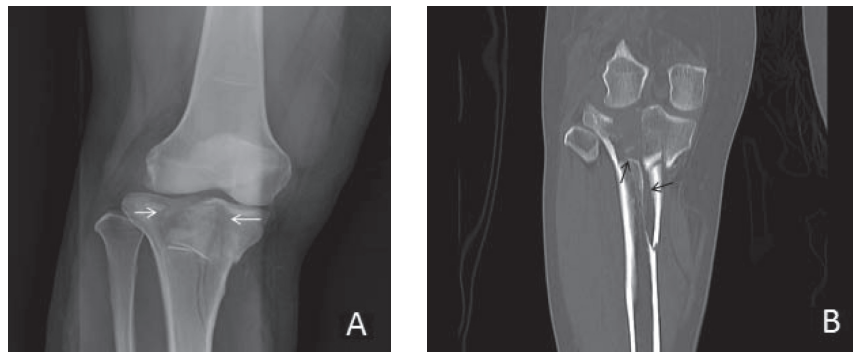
The right knee images of a 35-year-old female patient. (A) Antero-posterior XR image shows wedge fractures of the medial and lateral tibial plateau (white arrows), Schatzker V. (B) Coronal CT scan shows transverse subcondylar fracture with dissociation of the metaphysis from the diaphysis (black arrows), Schatzker VI.
